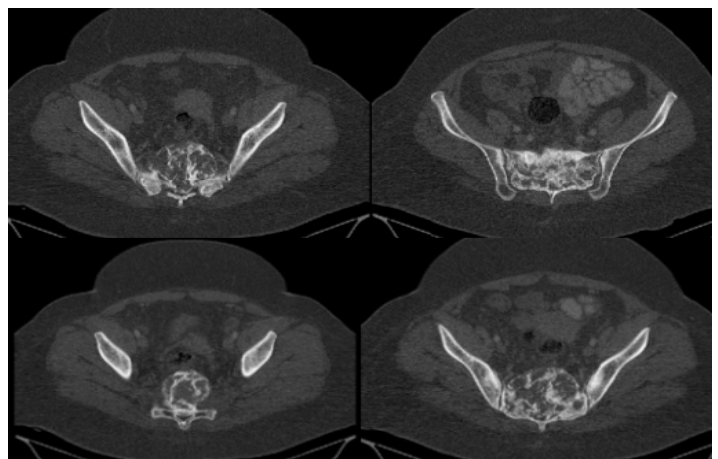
CT CT of a bone window after 2 years from definitive radiotherapy up to TD 64 Gy combined with targeted therapy.
